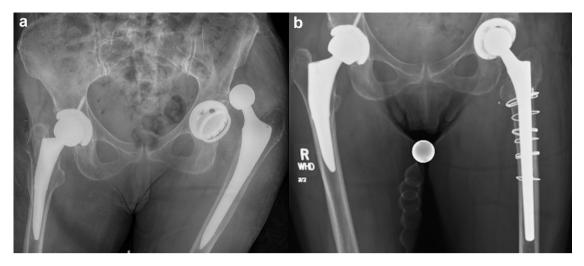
(a) Anteroposterior radiograph of the pelvis at second presentation showing superior dislocation of the femoral component with intact constrained liner and locking ring. (b) Final postoperative radiograph after revision left total hip arthroplasty, involving femoral component revision with head and liner exchange.
